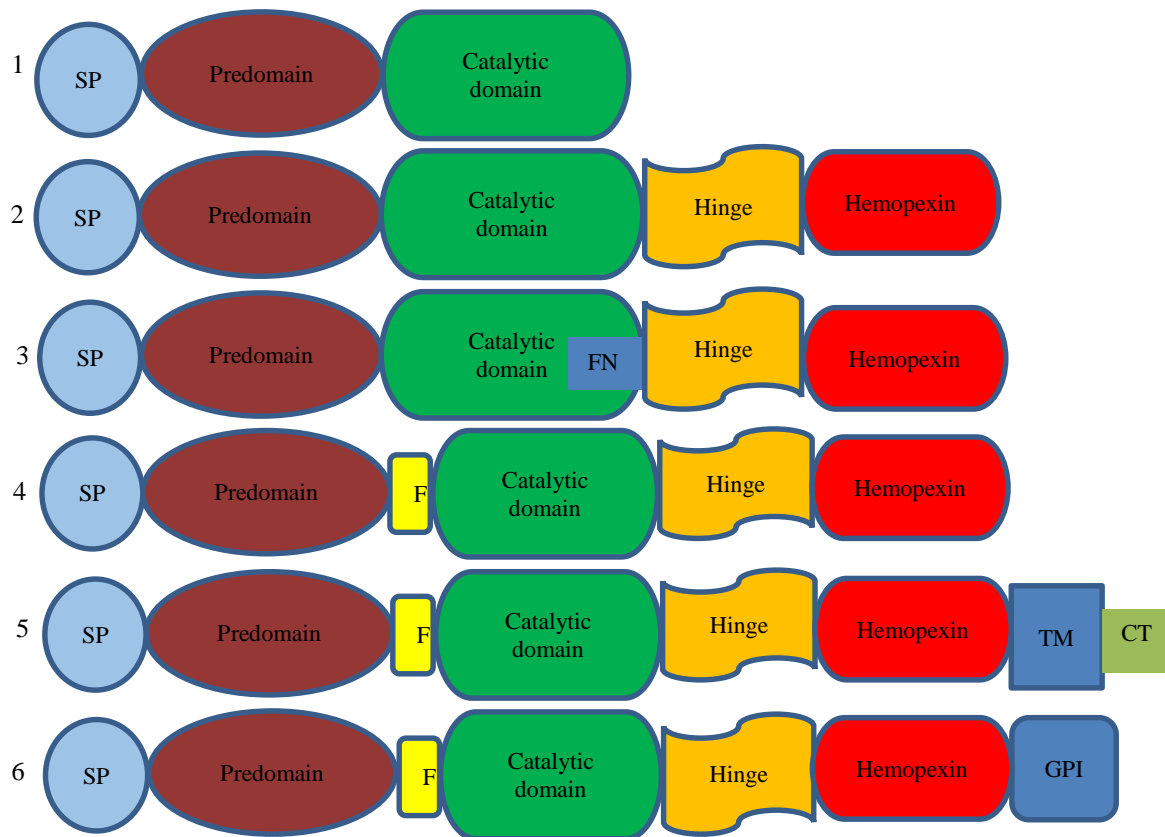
Representative figure showing the structure of MMPs. 1, matrilysins (MMP7 and 26); 2, collagenases (MMP1, 8,13); stromelysins (MMP3 and 10) and other MMPs (MMP12, 19, 20, 22 and 27); 3, gelatinases (MMP2 and 9); 4, secreted MMP11, 21 and 28; 5, transmembrane MT-MMPs (MT1-MMP, MT2-MMP, MT3-MMP and MT5-MMP); 6, GPI-anchored MT-MMPs (MT4-MMP and MT6-MMP). SP, signal peptide; FN, fibronectin; F, furin motif; TM, transmembrane; CT, cytoplasmic domain; GPI, glycosylphosphatidylinositol. Adapted from (Jaoude and Koh, 2016) with some modifications.
